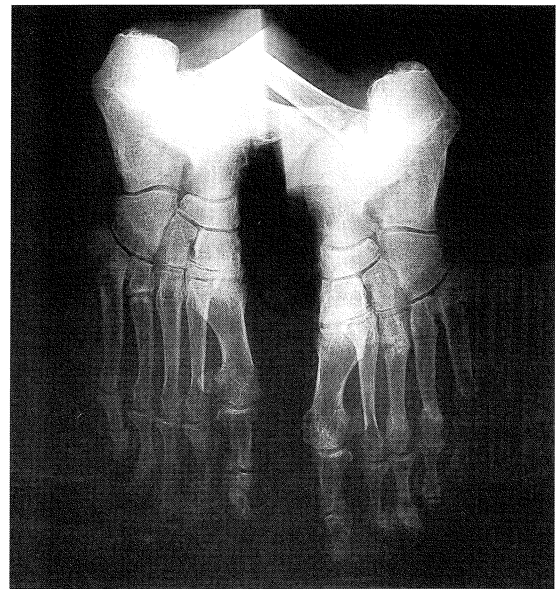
Radiographs of the feet
